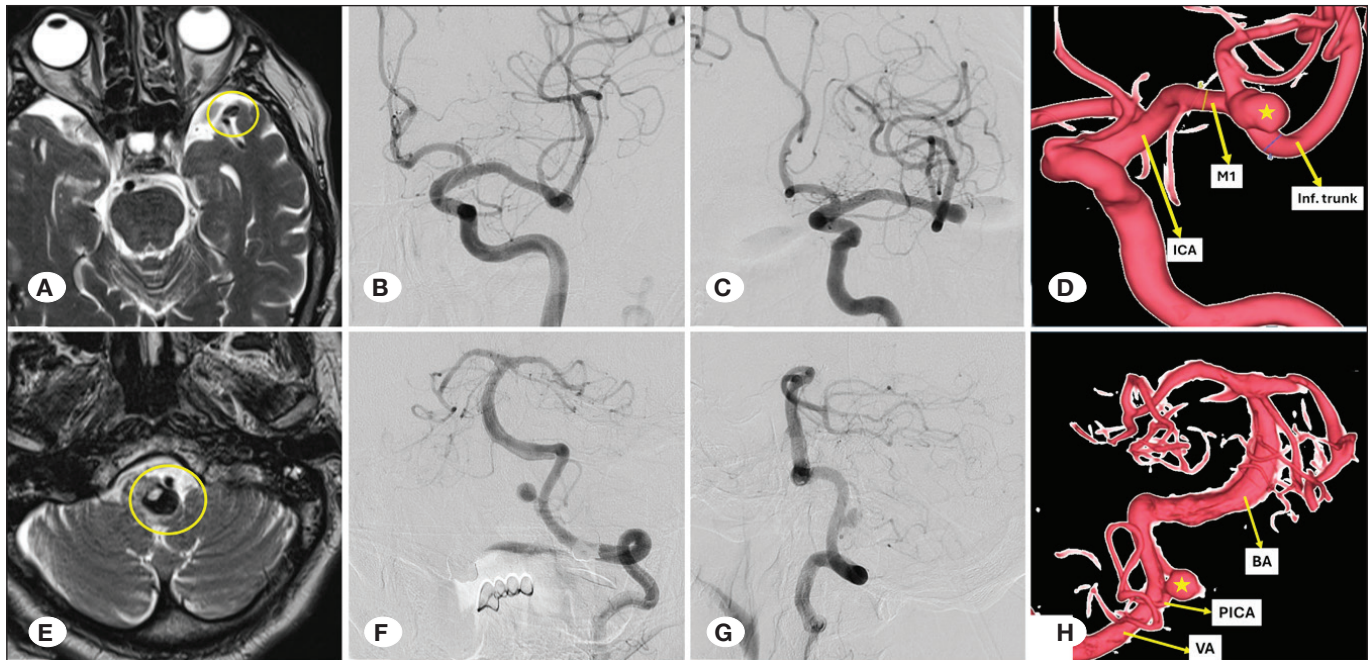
Pre-treatment imaging of a patient with non-ruptured left MCA bifurcation aneurysm and left PICA aneurysm. A) Axial T2-weighted MRI showing the left MCA bifurcation aneurysm. B) Anteroposterior (AP) view and C) oblique view DSA images demonstrating aneurysm location. D) 3D reconstructive DSA image showing a 7.3 × 4.2 mm saccular, wide-necked aneurysm. E) Axial T2-weighted MRI showing the left PICA aneurysm with a thrombosed component. F) AP view and G) lateral view DSA images demonstrating aneurysm location. H) 3D reconstructive DSA image showing a 12.4 × 8.3 mm saccular, wide-necked aneurysm.
